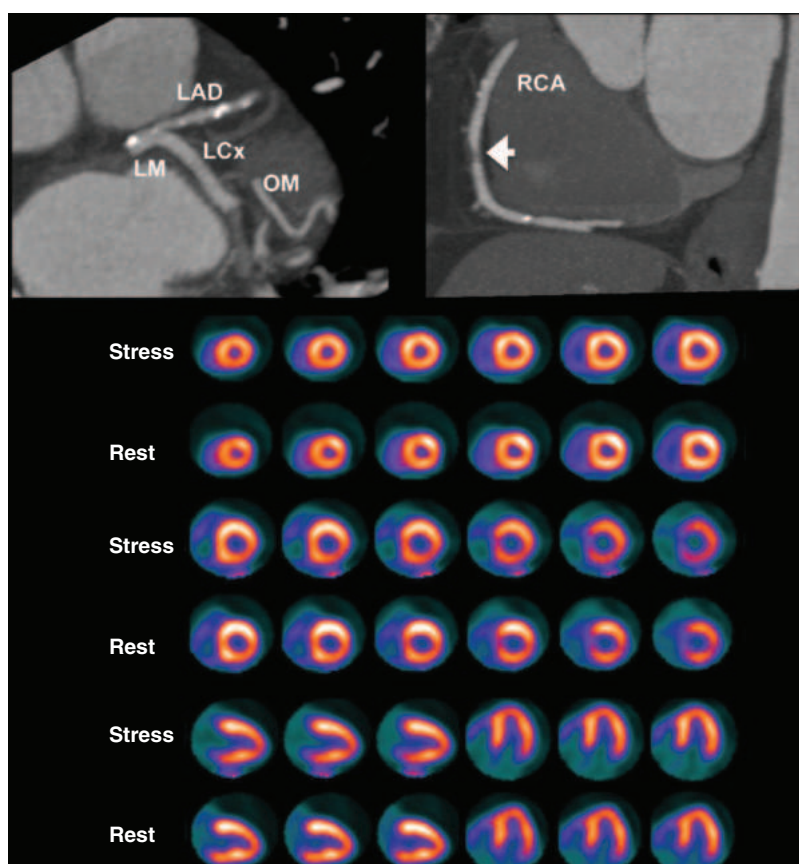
Selected views from coronary computed tomography angiographic (CTA) images (top panel) and stress and rest rubidium-82 myocardial perfusion positron emission tomography images (lower panel) obtained on a 64-year-old male patient with atypical angina. The CTA images demonstrate dense focal calcifications in the left main (LM) and left anterior descending (LAD) coronary arteries and a significant noncalcified plaque in the mid right coronary artery (RCA; arrow). The myocardial perfusion images demonstrated no evidence of flow-limiting stenosis. LCx, left circumflex artery; OM, obtuse marginal branch.
